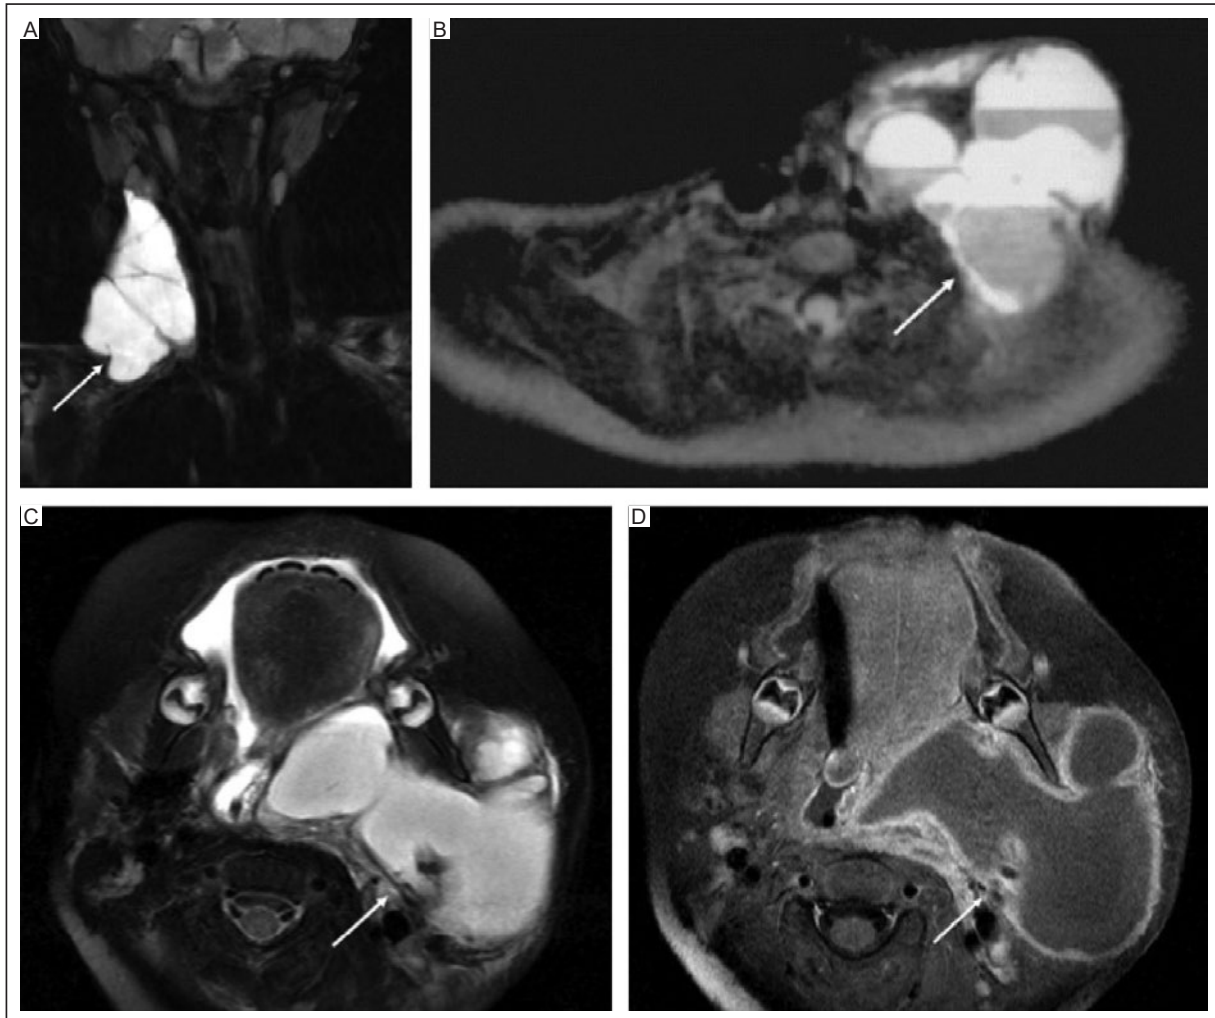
Lymphatic malformation. A: coronal T2-weighted fat-suppressed, and B: axial T2-weighted MRI of the neck in two different patients shows multilobulated T2 hyperintense lesions in the neck extending into multiple fascial planes with internal septations and fluid levels (arrows), consistent with macrocystic lymphatic malformations. C: axial T2-weighted fat-suppressed, and D: axial T1-weighted fat-suppressed post-contrast MRI of the neck in the same patient show a multi-lobulated but unilocular cystic lesion in the left neck extending into multiple fascial planes and thick peripheral enhancement consistent with an infected macrocystic lymphatic malformation (arrows).
